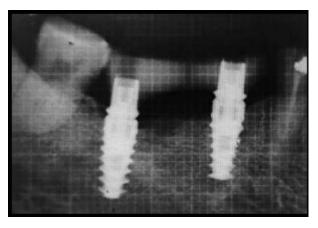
IOPA radiograph with grid after3 months
